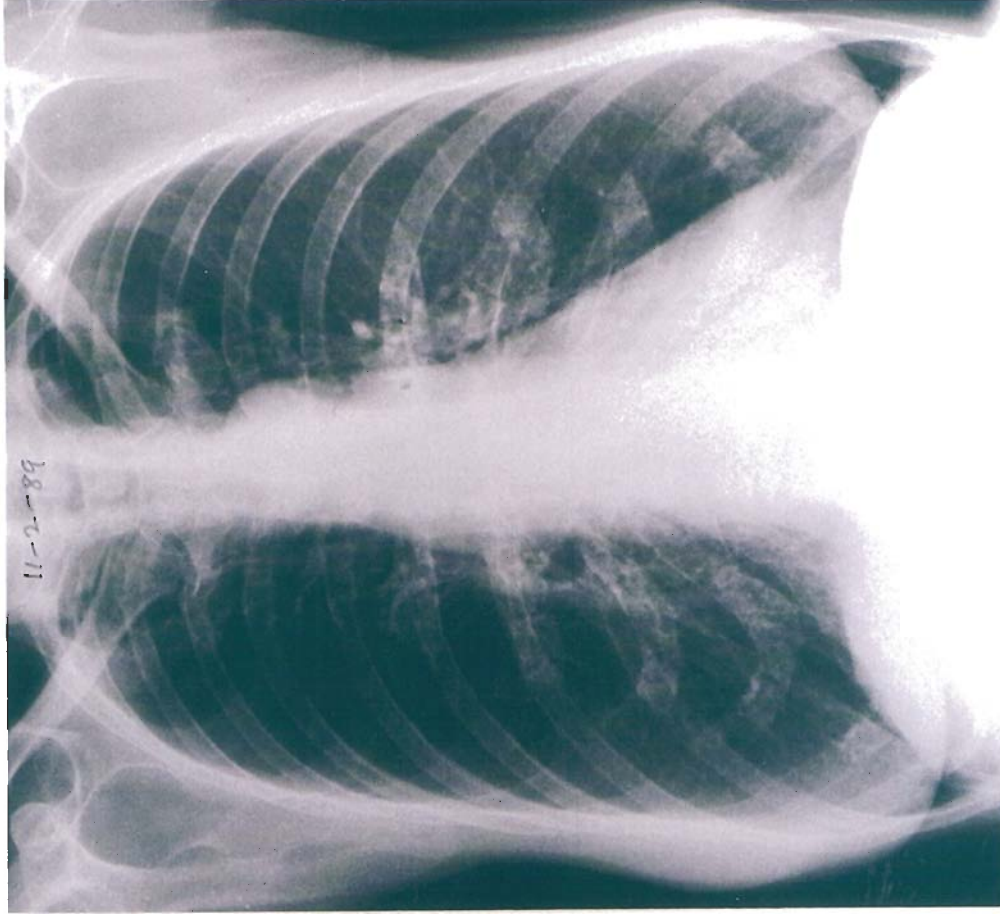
An x-ray of the patient in Figure A 14 months later. Four courses of glucose blocking agents plus microwaves in the intervening period had caused complete clearance of her residual abdominal disease and the secondary cancer in the left chest. X-ray taken 11 February 1989.
